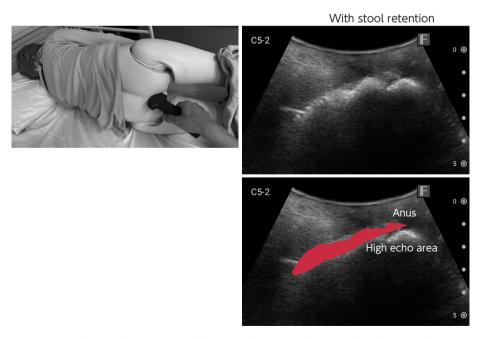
Ultrasound scanning and ultrasound images in the transgluteal approach.
